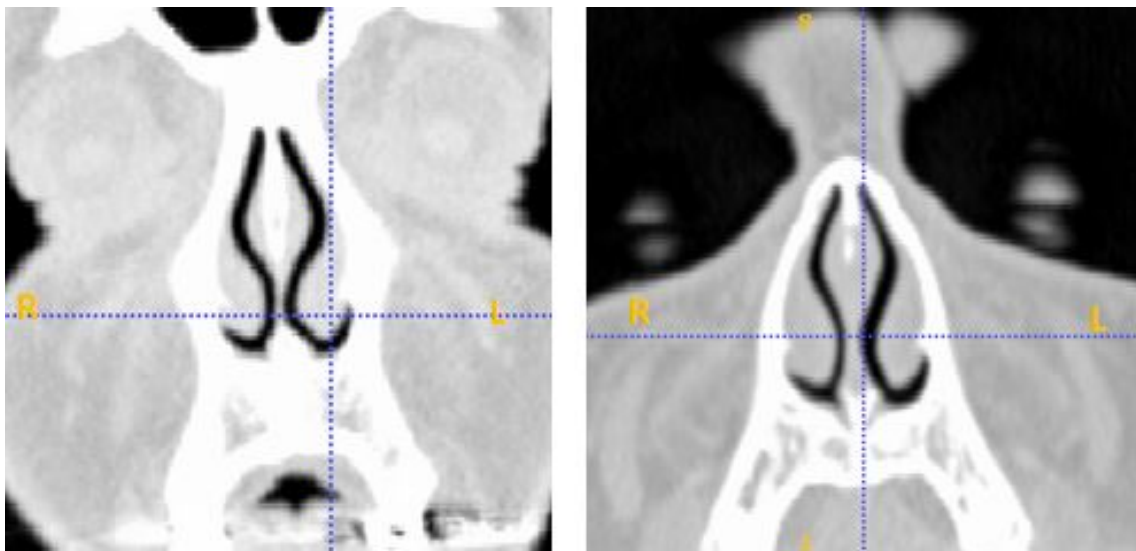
Coronal CT view of the nasal cavity pre(left)- and post(right)-operative
